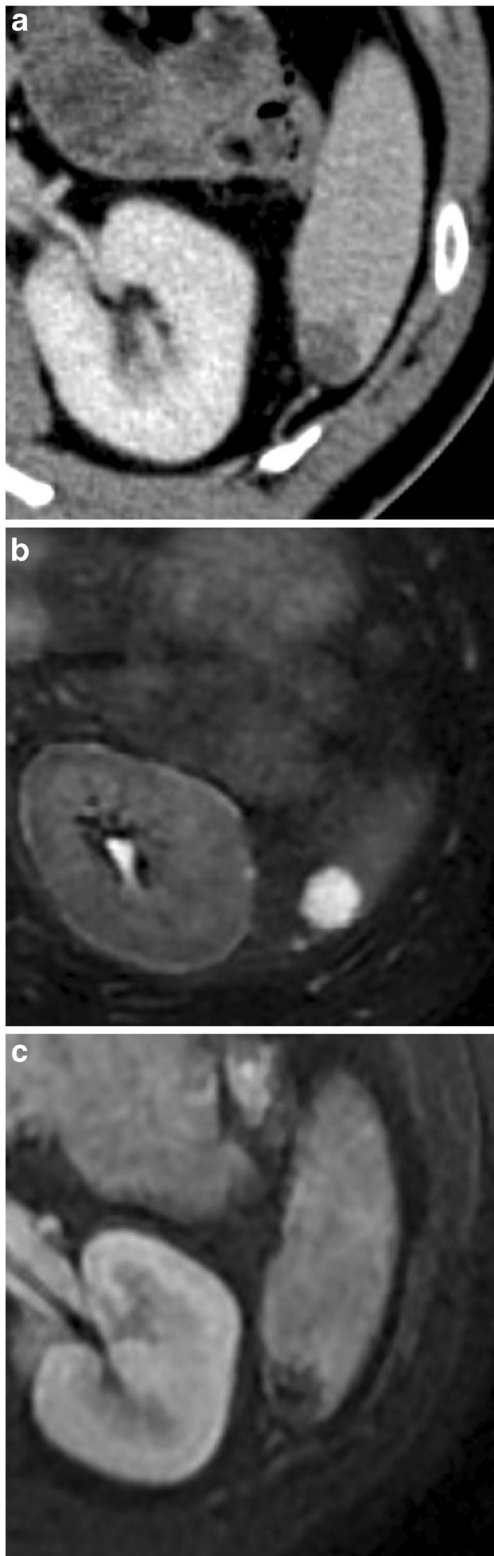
A 45-year-old male patient with blunt abdominal trauma after fall. a Transverse portal-venous phase CT shows a hypodense lesion of the posterior pole of the spleen. b T2-weighted MR images at the same level demonstrate a well demarcated, homogeneously hyperintense lesion. c Contrast-enhanced T1-weighted MR images in the venous phase shows a nodular, peripheral enhancement indicating hemangioma
